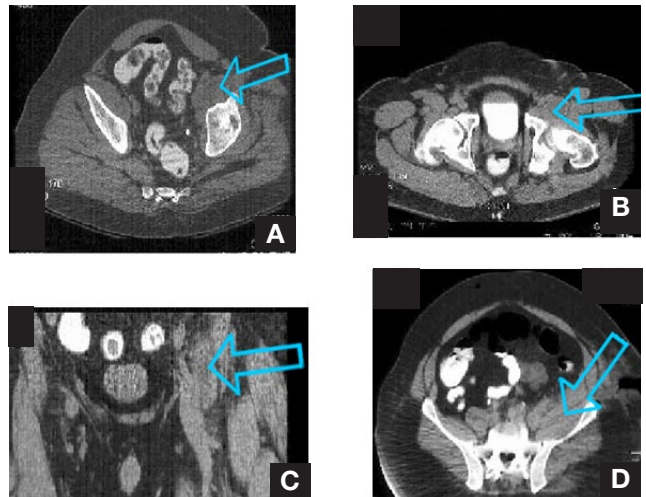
In case 3, (A) computed tomography (CT) scan obtained on admission showed enlarged inflamed iliopsoas muscles. (B) Coronal CT scan obtained on admission showed soft-tissue enlargement of the iliopsoas extending to the hip and proximal femur. (C) CT scan obtained on admission revealed enlarged inflamed iliopsoas muscle. (D) CT scan obtained 10 days after initial drainage (5 days after excisional débridement of femoral head) showed large iliopsoas muscle.
